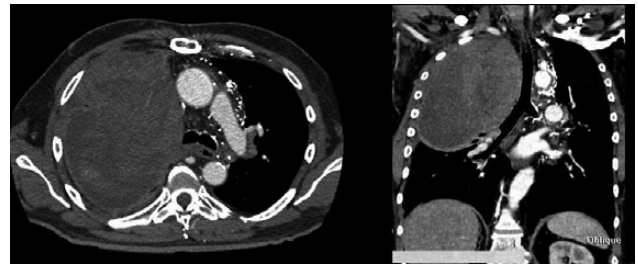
The axial and coronal CT scans of the second case
